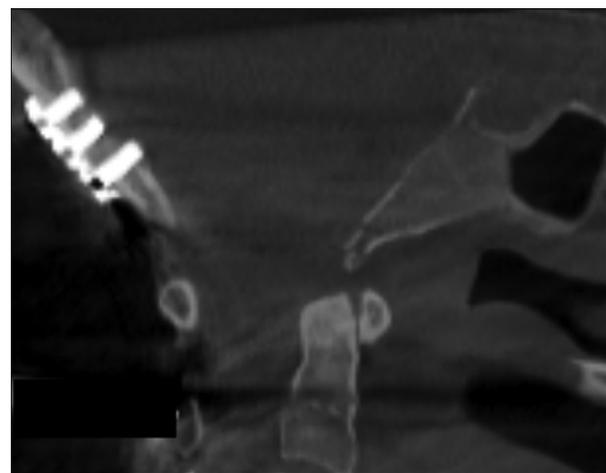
Postoperative computed tomography cervical spine (mid-sagittal view) shows reduction of the inferior clivus fracture.
